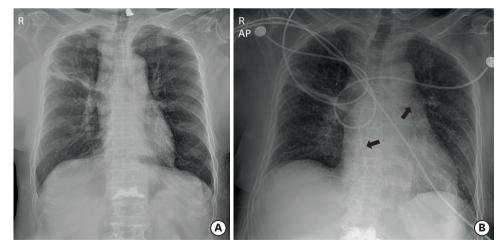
Chest radiography before (A) and after (B) percutaneous vertebroplasty. Linear radio-opaque materials (arrows) were observed within heart and left hilum.
